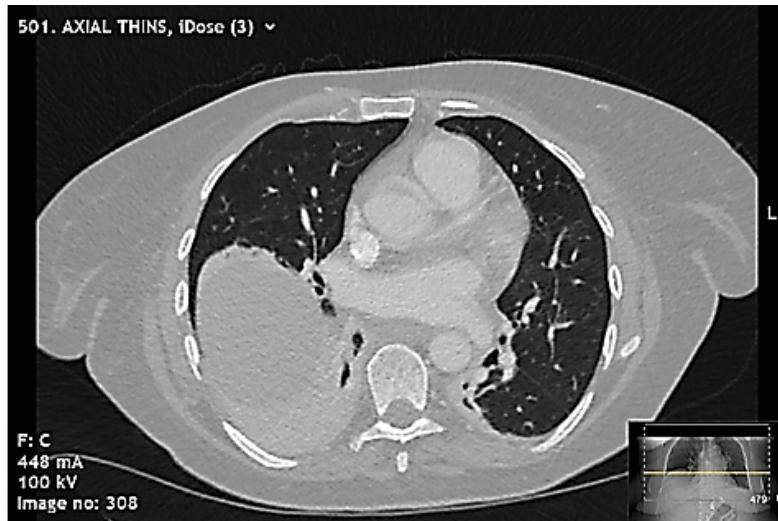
Selected slice from CT pulmonary angiogram demonstrating right lower zone collapse with mild inflammatory changes, mild pericardial thickening, and no pericardial effusion.
